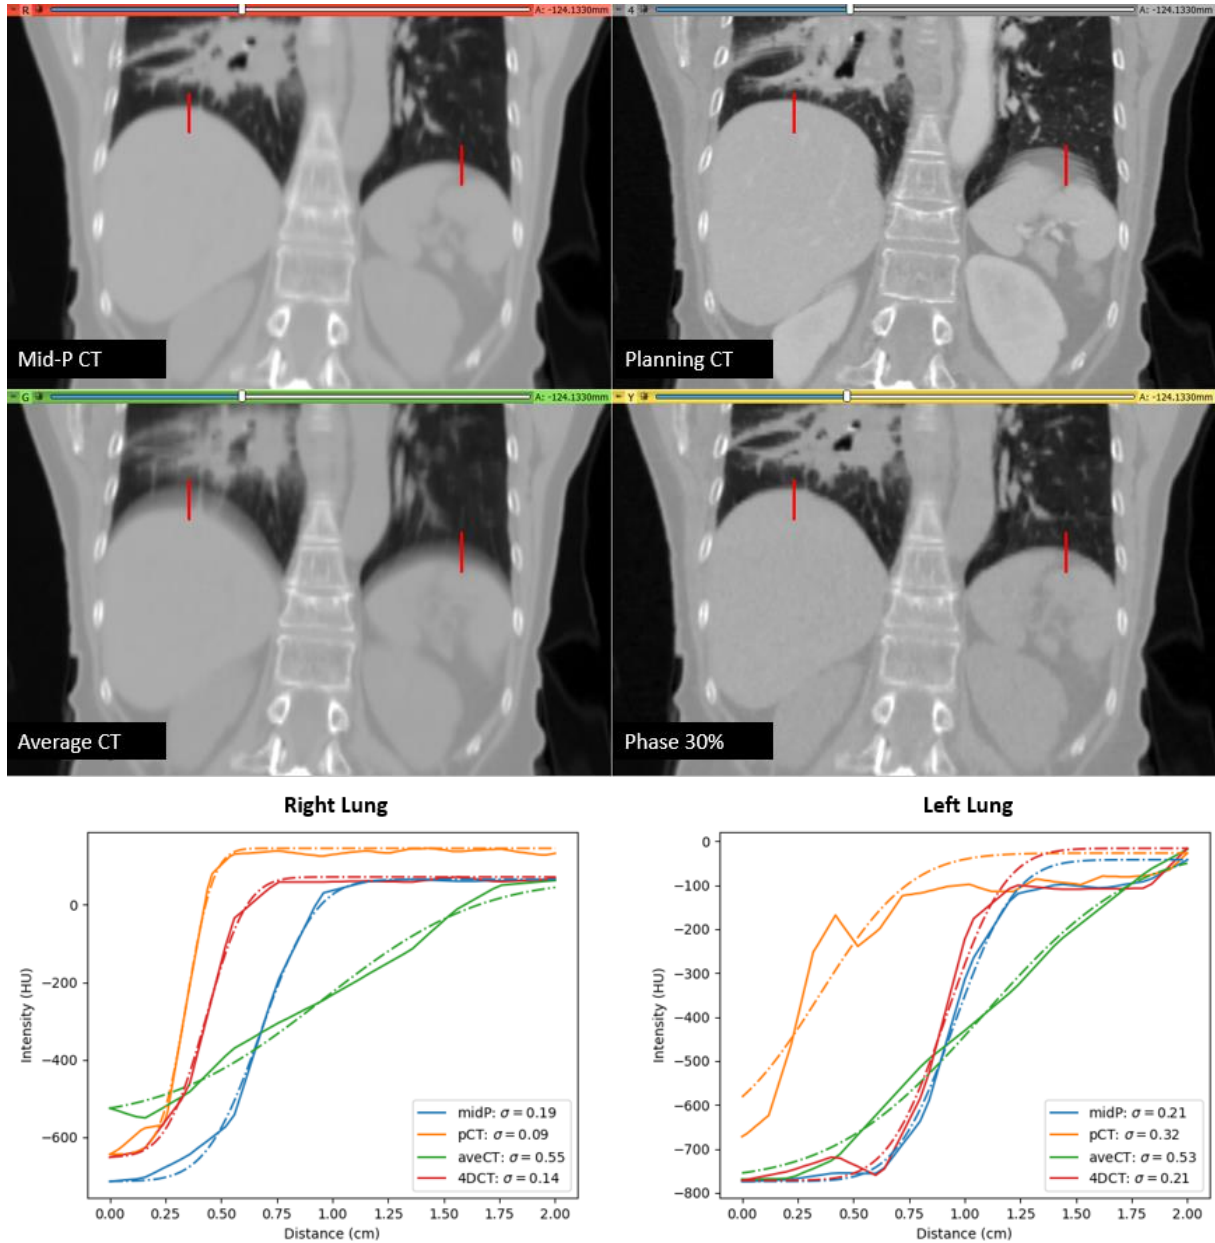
Image sharpness comparison between the Mid-P CT scan reconstructed by the *RunMidP* module, Average CT, free-breathing planning CT and one 4DCT frame (phase 30%) for Patient5. Intensity values along the red lines were plotted for the right and left diaphragm-lung interface. Standard deviations of the fitted cumulative Gaussian distribution were taken to evaluate the image sharpness of each scan (bottom row).
